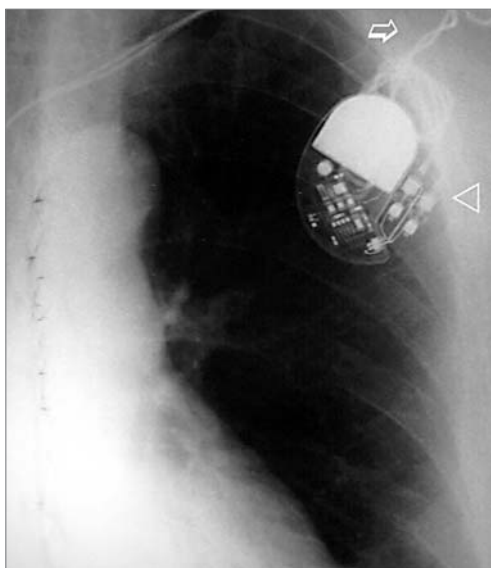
Chest X-ray showing that the pulse generator header has been reorientated counter clockwise (arrowhead) and the leads are twisted (arrow), documenting the diagnosis of twiddler's syndrome.
